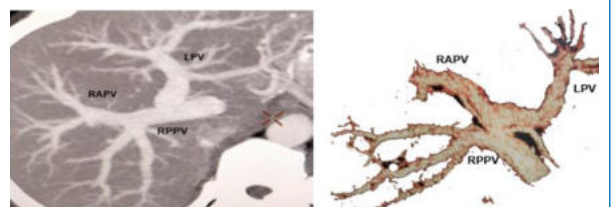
CT axial MIP reformatted and VR image in the portal venous phase showing Trifurcation of RPPV
